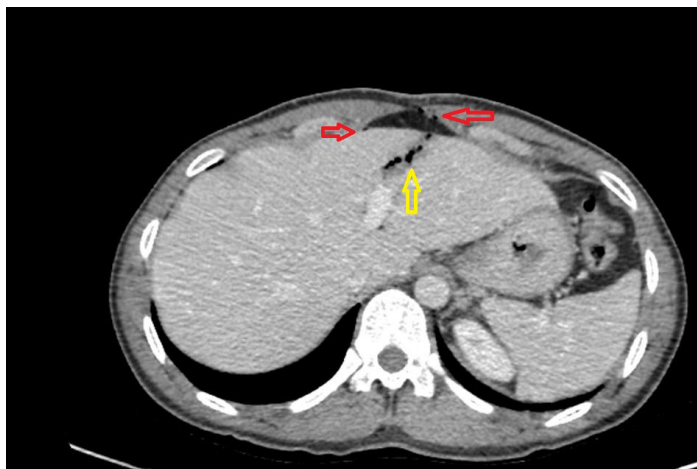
Contrast enhanced CT image showing a Grade II liver laceration. Yellow arrow indicates intraparenchymal free air within the liver, Red arrows indicate , intraperitoneal free air adjacent to the liver.
